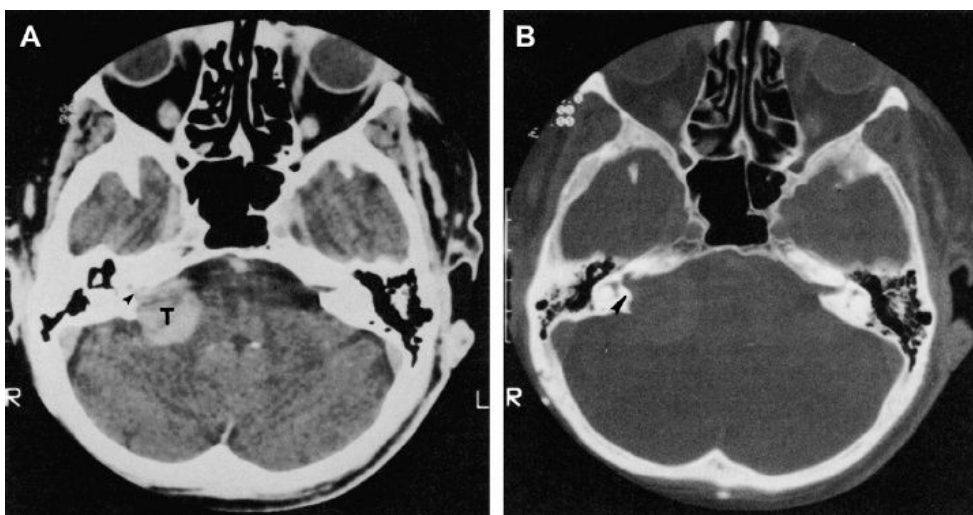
(A) A VS with high resolution computed tomography showing contrast. Soft tissue algorithms show the tumor (T) protruding into the internal auditory canal (IAC). (B) A Bone algorithm shows the enlargement of the IAC
